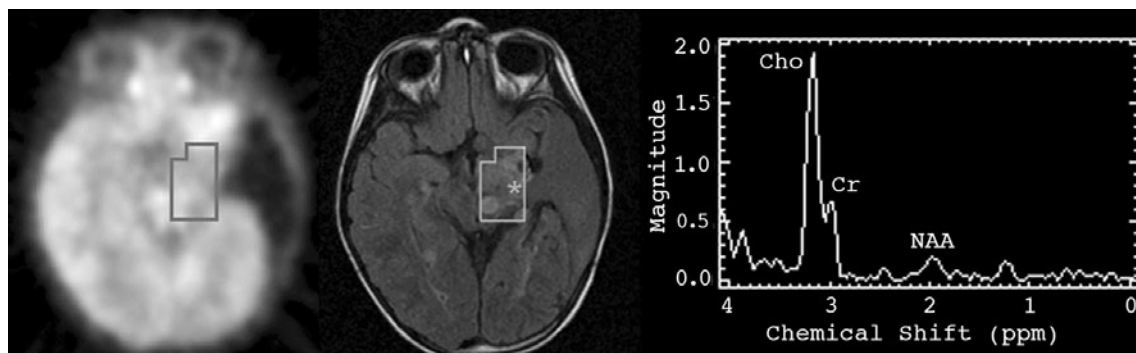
Comparison of metabolic activity determined by FDG-PET and MRSI. Results obtained by MRSI (right) were classified as highly active (Max Cho:NAA = 6.7). Corresponding area on FDG-PET
